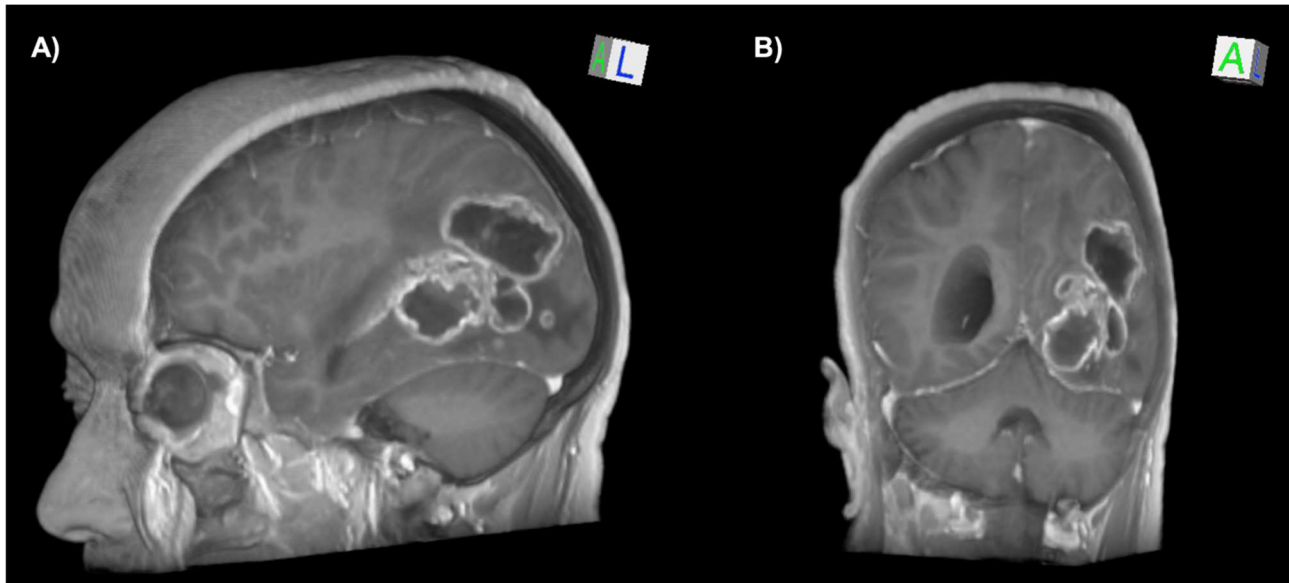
Diffuse high-grade astrocytic glioma appearance on T1-weighted post-contrast sequences: A) 3D sagittal reconstruction; B) 3D coronal reconstruction.
